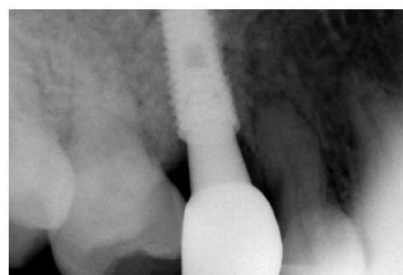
Postoperative X-ray
